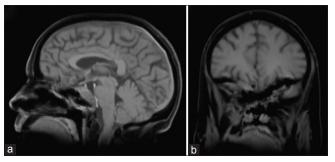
Postoperative T1-magnetic resonance imaging ([a], sagittal, [b], coronal) after an early injection of gadolinium showing large lesion debulking with residual mass in the clival, right subfrontal area, and the right orbit
